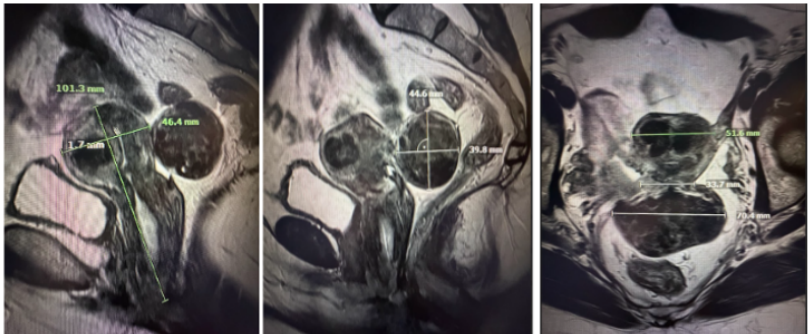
Pelvic MRI demonstrating an enlarged fibroid uterus with a pedunculated posterior fibroid and marked cervical elongation. MRI of pelvis shows a 10 cm uterus with Approximately 4 uterine fibroids were noted, with a 7 cm x 4.5 cm x 4 cm pedunculated fibroid on the posterior uterine body. In addition, the cervix was markedly elongated.
